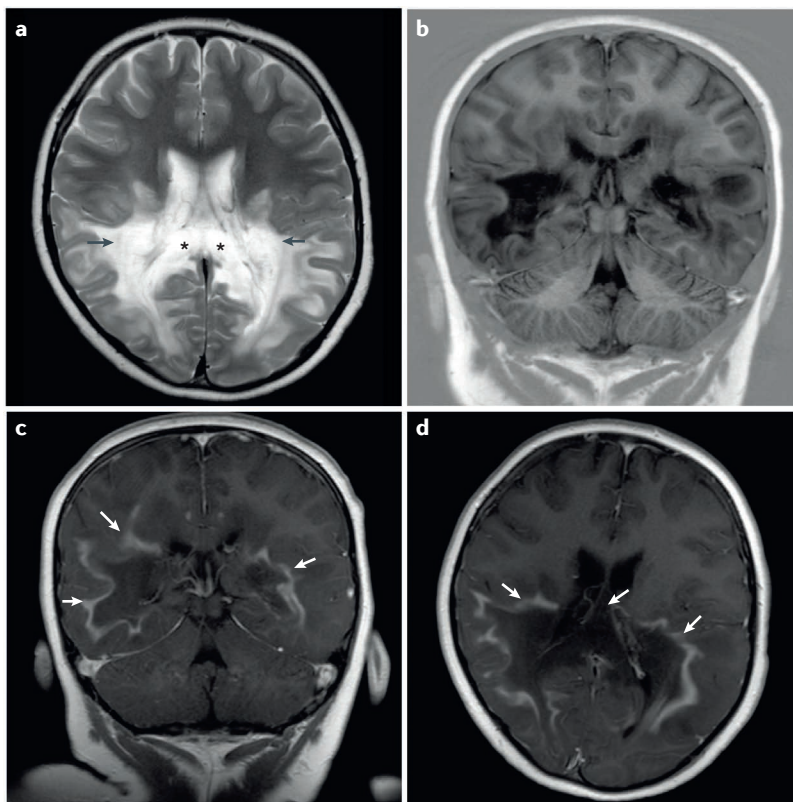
MRI of a 6-year-old boy with cerebral ALD. Note the extensive white matter lesions involving the parieto-occipital white matter (arrows) and splenium of the corpus callosum (asterisks). a | The lesion shows increased signal intensity on T2-weighted images. b | the lesion has decreased signal on T1-weighted images. c | extensive gadolinium enhancement just beyond the leading edges of the lesion on coronal. d | axial T1-weighted images after gadolinium administration.
